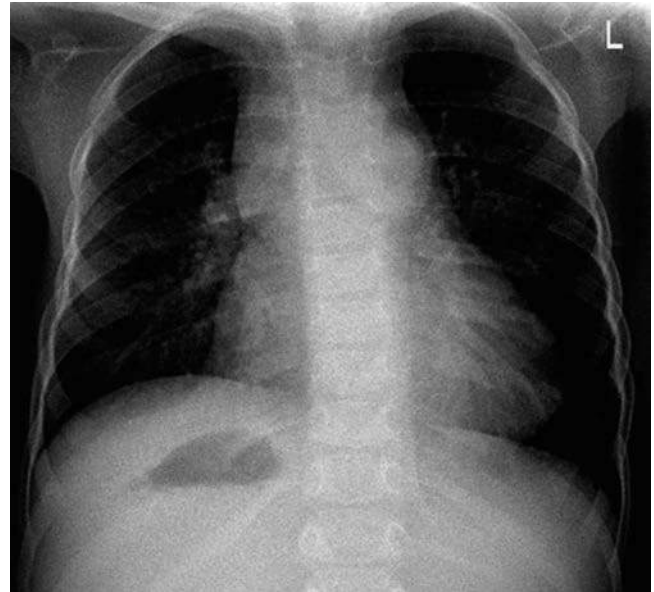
Anteroposterior chest radiograph in a patient with isomerism of the left atrial appendage ILAA shows left-sided cardiac apex but the stomach bubble is on the right. Moreover, the main bronchi appear symmetrical with both having left-sided morphology (widening of the mediastinum due to right Blalock shunt).
